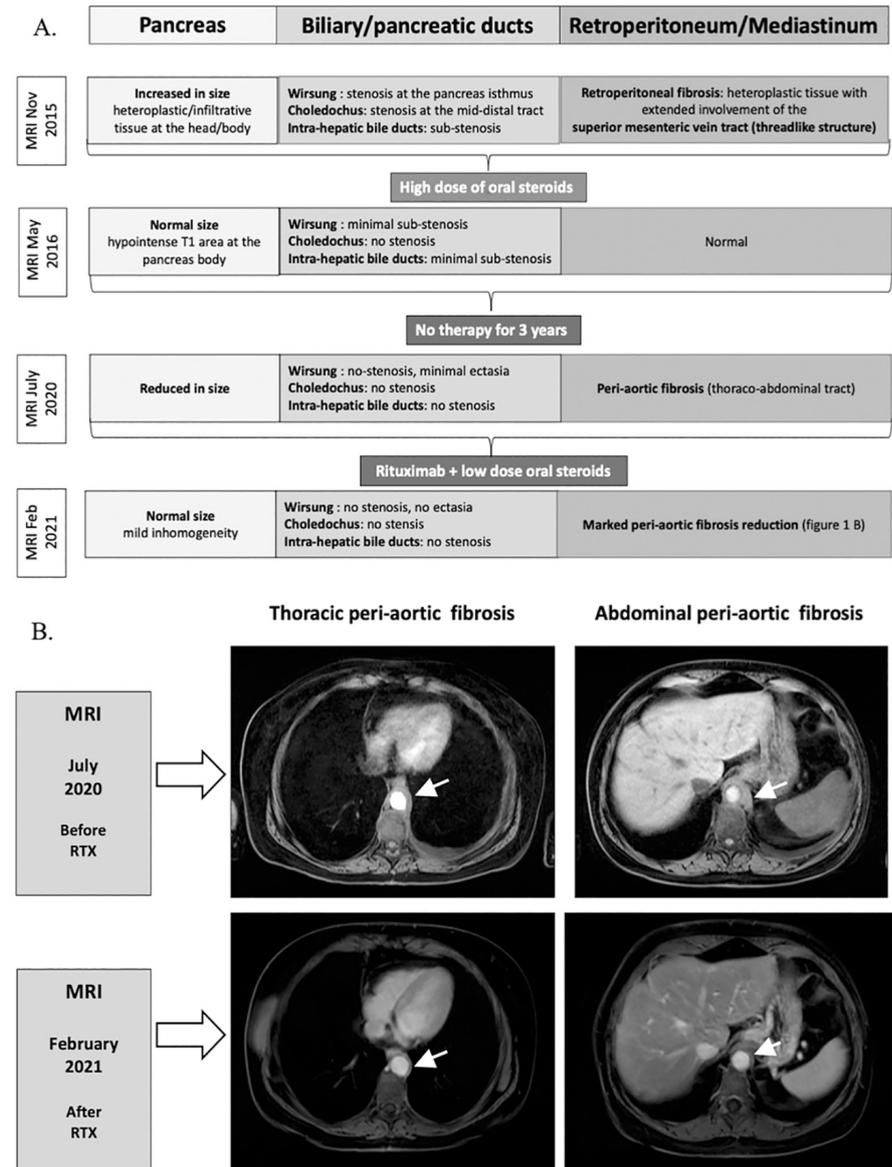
A: Treatments and their effect on the involved tissues during the follow-up period. B: The peri-aortic fibrosis before and six months after rituximab (RTX) and steroids, on MRI.
